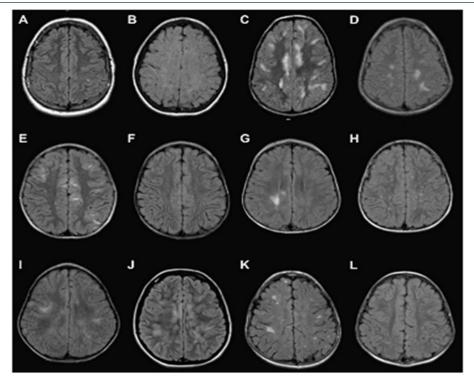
Axial FLAIR images of brain showing multiple hyperintense (demyelinating) lesions of ADEM involving different areas of cerebral hemispheres
